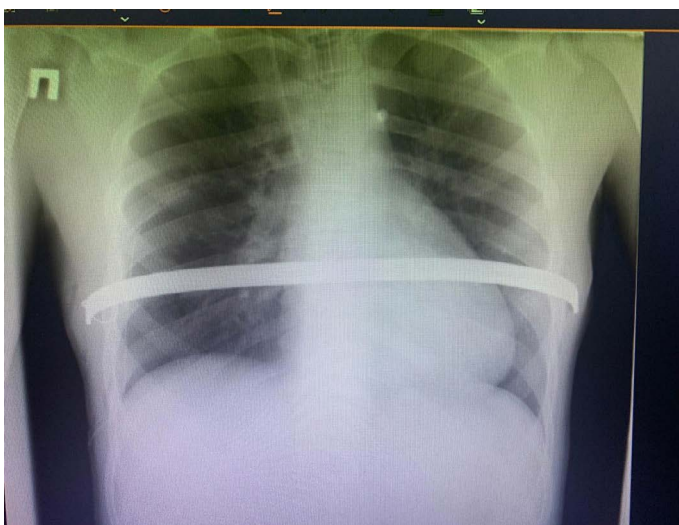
Case N1: Patient J.K. X-ray picture with metal implant after surgery.
